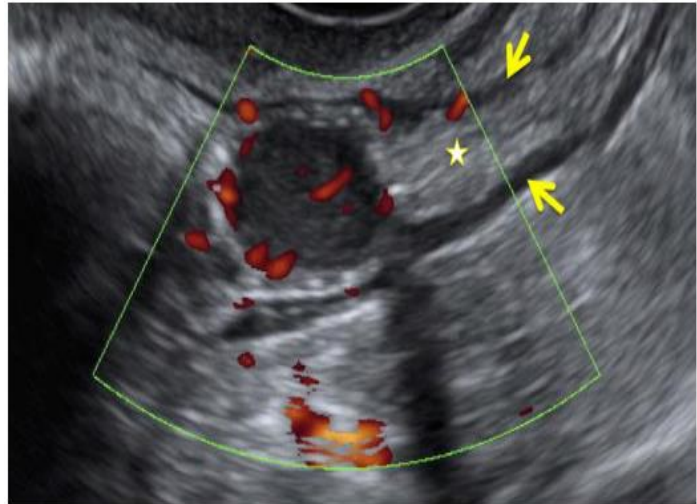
Ultrasonographic transvaginal showing intraluminal solid mass, with increased peripheral and central vascularity of 12x11 mm
